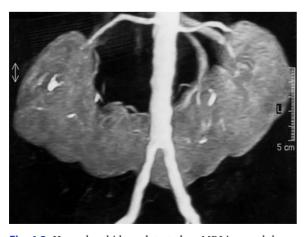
Horseshoe kidney detected on MRI in an adult
